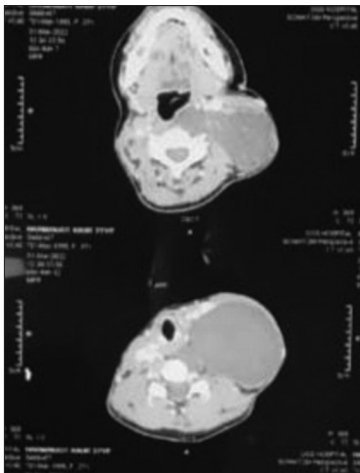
Axial contrast-enhanced computed tomography scan showing the location of tumor in the left lateral aspect of the neck
